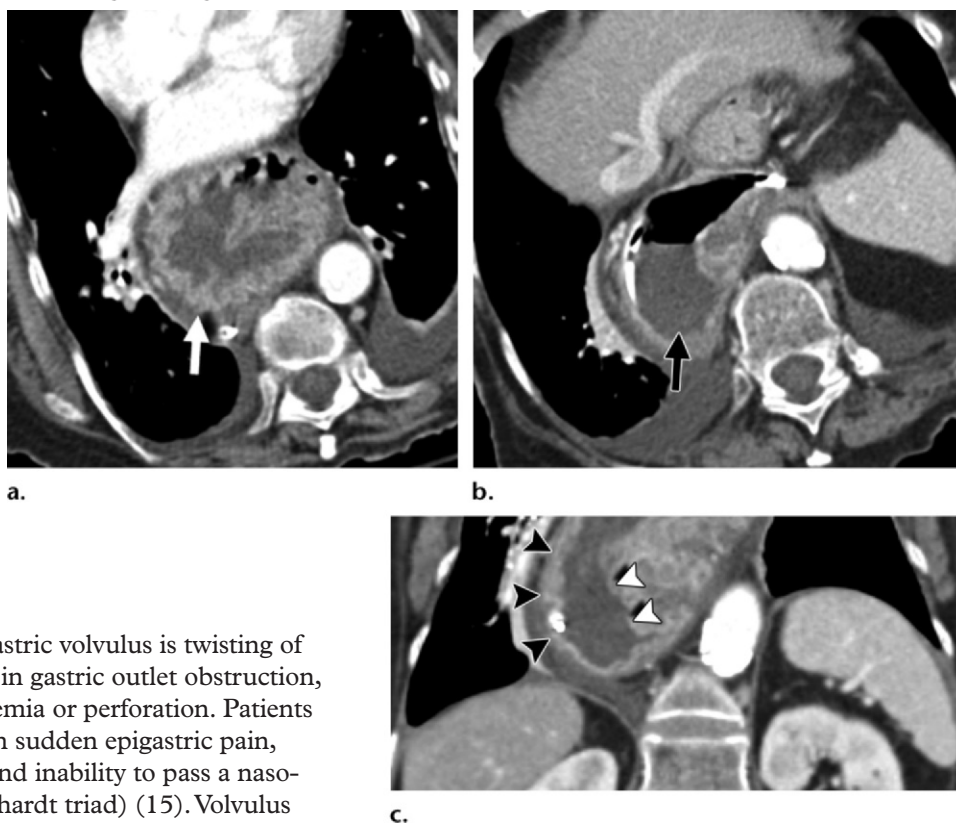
Organoaxial volvulus in a patient with intractable vomiting. (a) Axial CT image shows a hiatal hernia with the gastric body (arrow) located superiorly. (b) Axial CT image, in a different section, shows that the fundus (arrow) is located inferiorly to the gastric body. (c) Coronal CT image shows the greater curvature (black arrowheads) superior and to the right of the lesser curvature (white arrowheads), compatible with organoaxial gastric volvulus.
